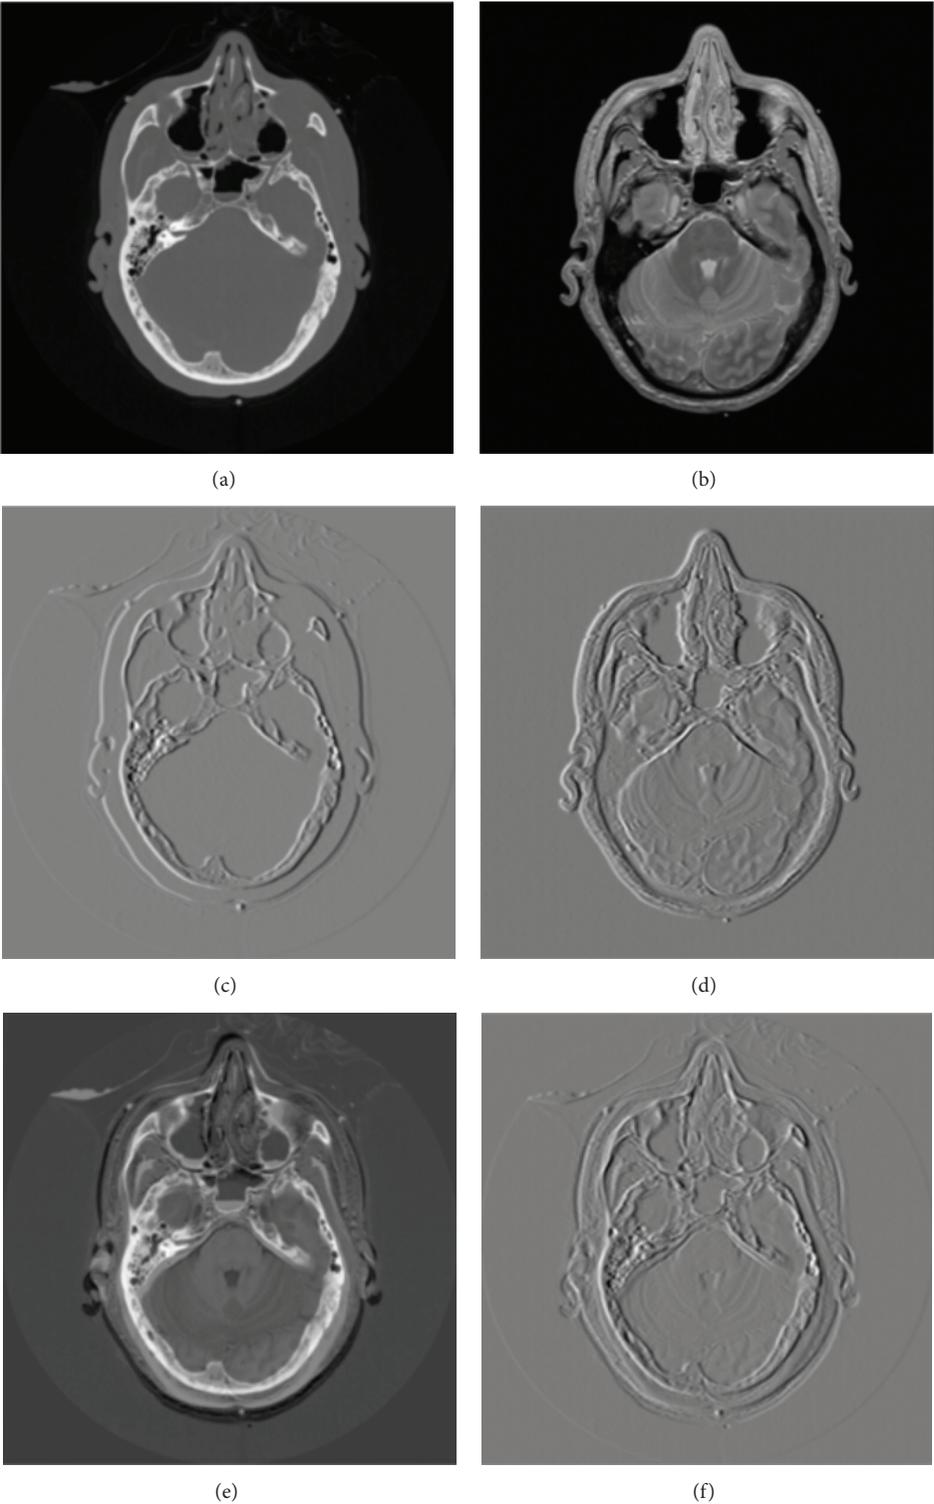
(a) CT image; (b) corresponding MRI image; (c) the first-order gradient of CT; (d) the first-order gradient of MRI; (e) CT and MRI images subtraction; (f) gradient images subtraction. (a) and (b) are obtained from *Visible Human Project* [http://www.nlm.nih.gov/research/visible/visible\\_gallery.html](http://www.nlm.nih.gov/research/visible/visible_gallery.html).
